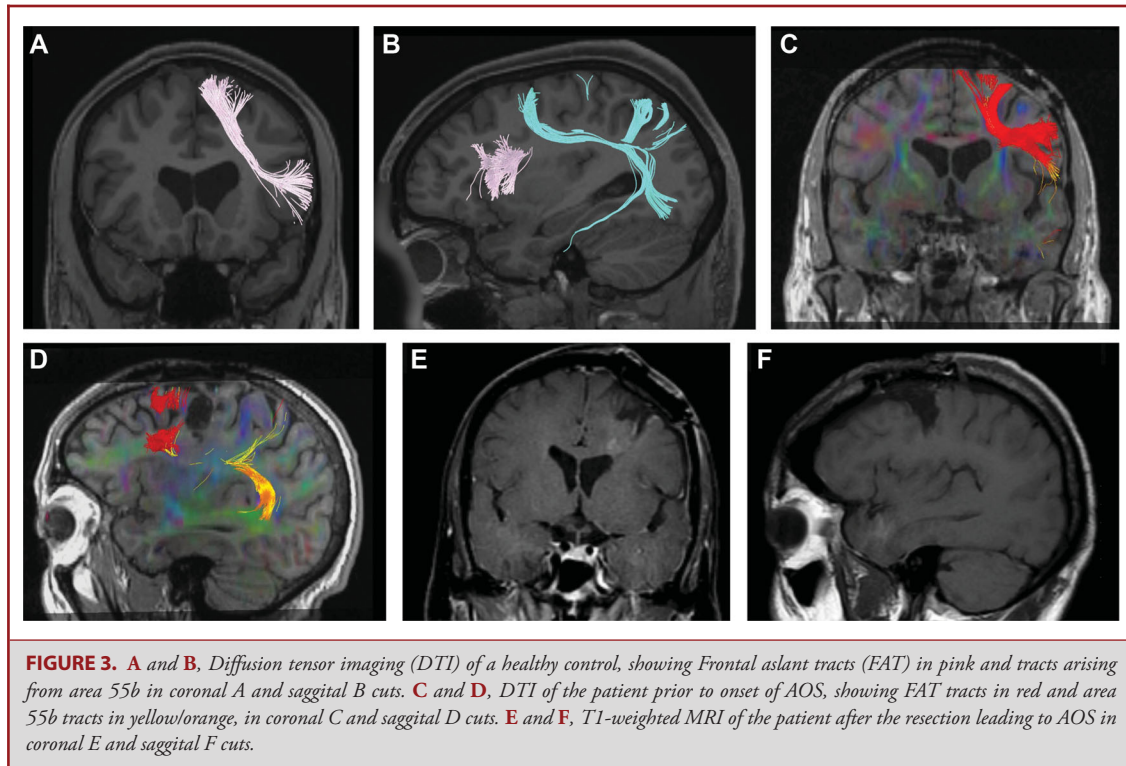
A and B, Diffusion tensor imaging (DTI) of a healthy control, showing Frontal aslant tracts (FAT) in pink and tracts arising from area 55b in coronal A and sagittal B cuts. C and D, DTI of the patient prior to onset of AOS, showing FAT tracts in red and area 55b tracts in yellow/orange, in coronal C and sagittal D cuts. E and F, T1-weighted MRI of the patient after the resection leading to AOS in coronal E and sagittal F cuts.
